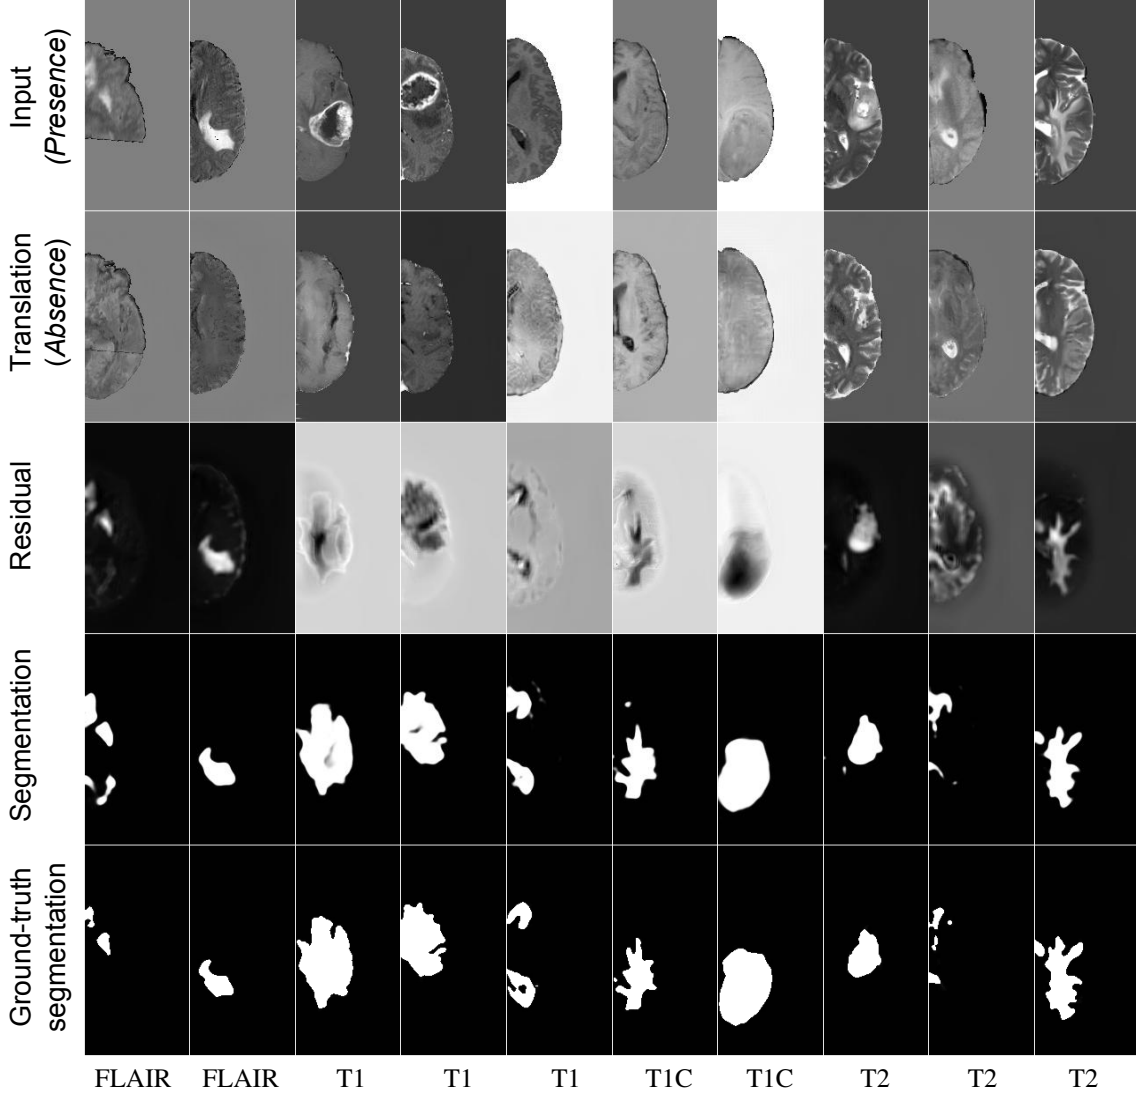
Example of image segmentation and translation from *Presence* to *Absence* domains for BraTS. Different MRI sequences (image channels) are arranged in columns.
